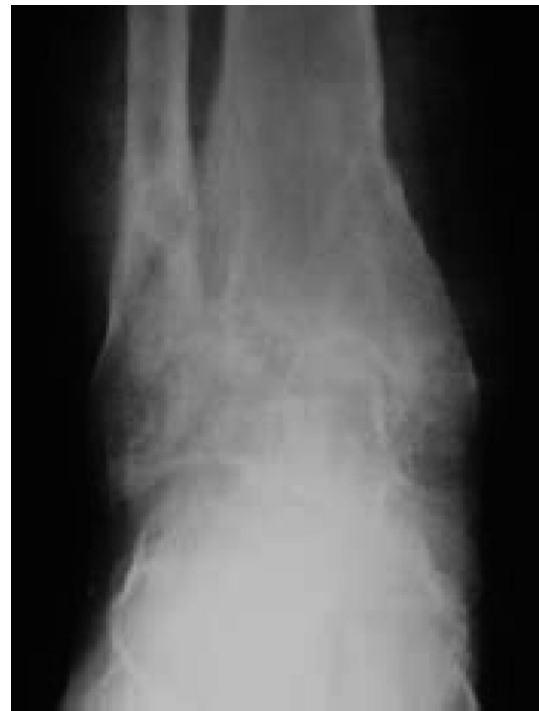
Anterior-posterior ankle weightbearing x-ray, 36 months post operative film.
